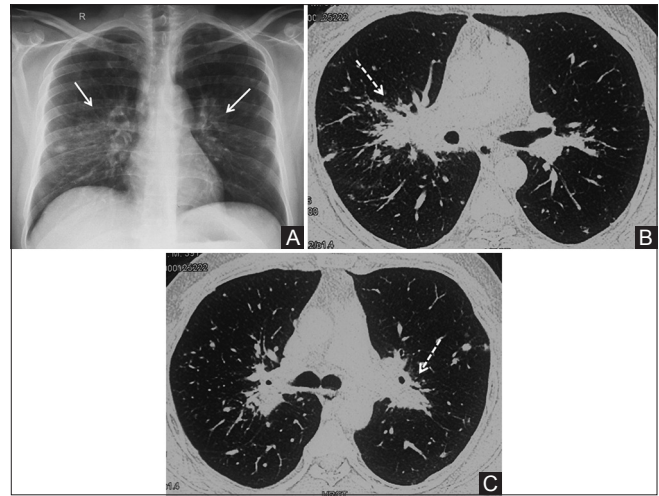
(A-C): Sarcoidosis: Parenchymal masses (A) Chest X-ray (CXR) shows bilateral parahilar ill-defined consolidation (right more than left) (white arrow). Multiple separate well-defined discrete nodules seen in bilateral upper and mid zone. (B and C) Axial CT image (lung window) shows bilateral confluent parahilar masses extending to upper lobes (dashed arrows). Multiple discrete perilymphatic and random nodules seen in bilateral lung parenchyma
